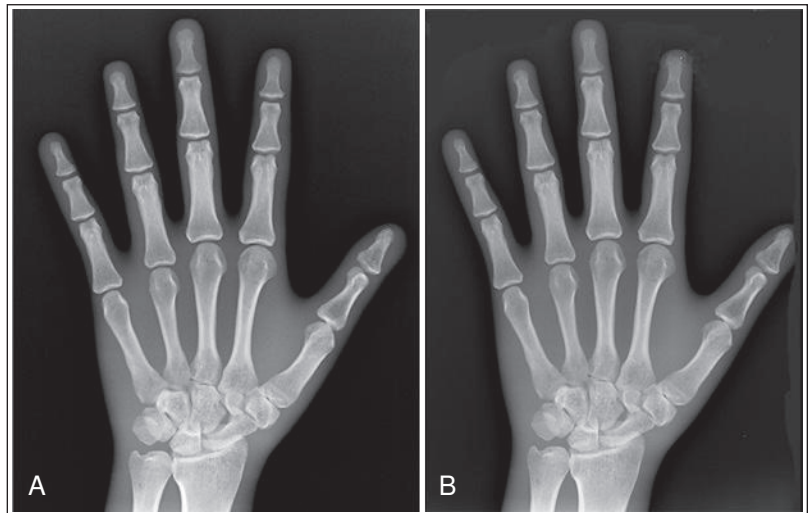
SID and spatial resolution. The longer the SID, the sharper the recorded details because the beams recording the detail edges are nearer to the CR and recorded with straighter x-rays.
